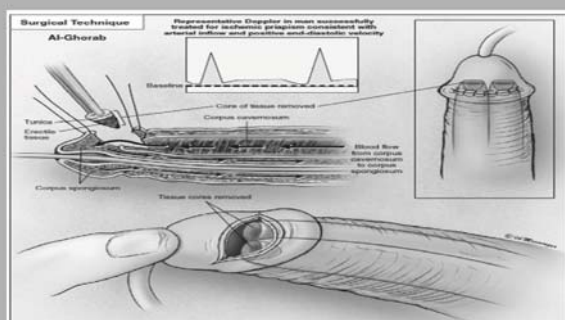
Open corporogranular shunt is indicated if percutaneous shunting fails to re-establish cavernous blood inflow (test measured by color Doppler ultrasonography). The Al-Ghorab shunt requires the resection of circular stone segments of distal tunica albuginea (5-10 mm). J Urol 2006;174:749-752
